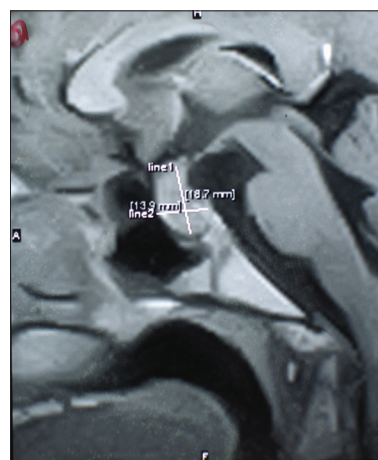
Magnetic Resonance Imaging pituitary – A sellar mass (18.7 × 15.7 × 13.9) mm in size
